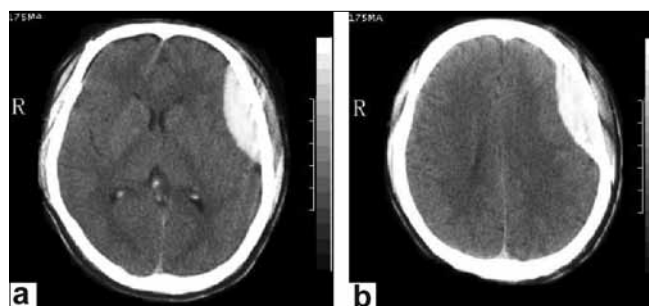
(a, b) Non-contrast axial head CT revealing left temporo-parietal hyperdensity. No soft-tissue swelling, fractures, or other radiographic signs of trauma are present (volume of hematoma is approximately 30 ml)
